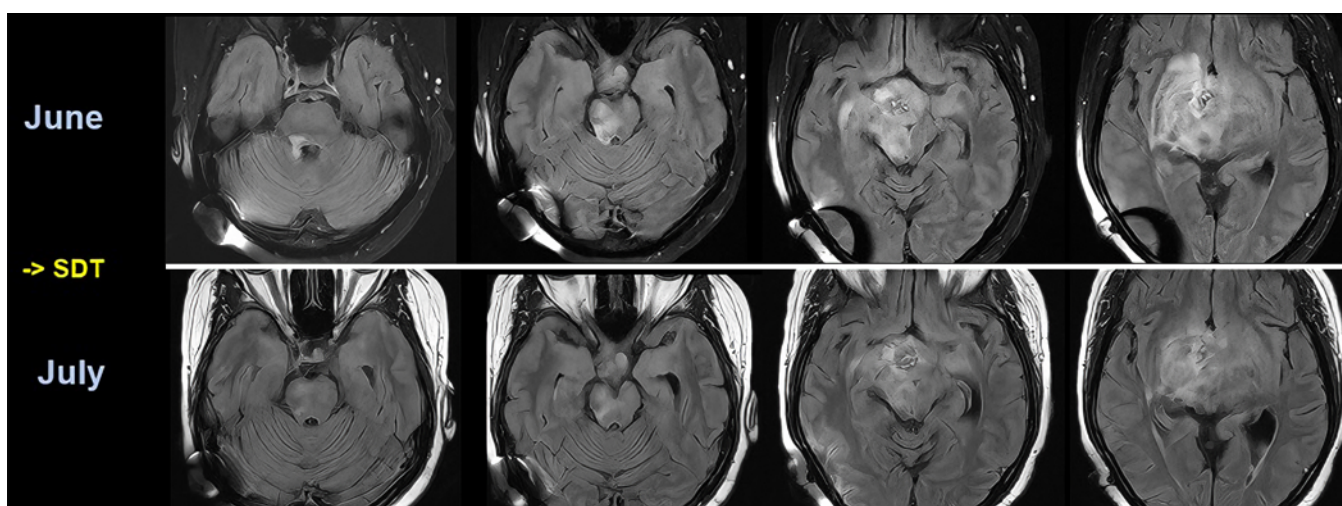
Upper Row: Axial MRI sections obtained after combined therapy of lomustine and bevacizumab prior to SDT. Lower Row: Axial MRI sections obtained after the first round of SDT (52 mL), with each image in this row corresponding to the same-level axial slice from the row above. Imaging demonstrates reduction in FLAIR hyperintensity at the site of initial SDT sonication.
